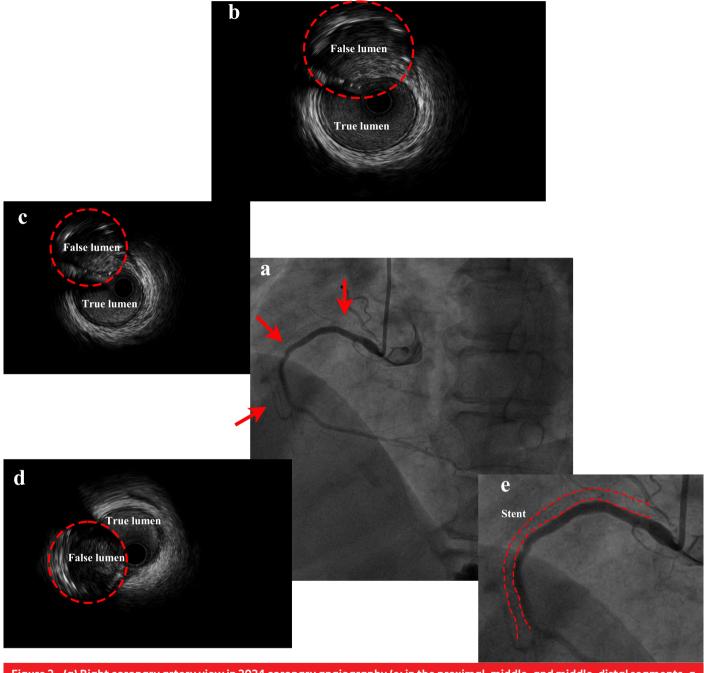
(a) Right coronary artery view in 2024 coronary angiography (e: in the proximal, middle, and middle-distal segments, a stent shadow is observed accompanying the vessel); (b) 2024 intravascular ultrasound imaging of the right coronary artery demonstrates the proximal segment; (c) 2024 intravascular ultrasound imaging of the right coronary artery demonstrates the middle segment; (d), 2024 intravascular ultrasound imaging of the right coronary artery demonstrates the middle-distal segment.
